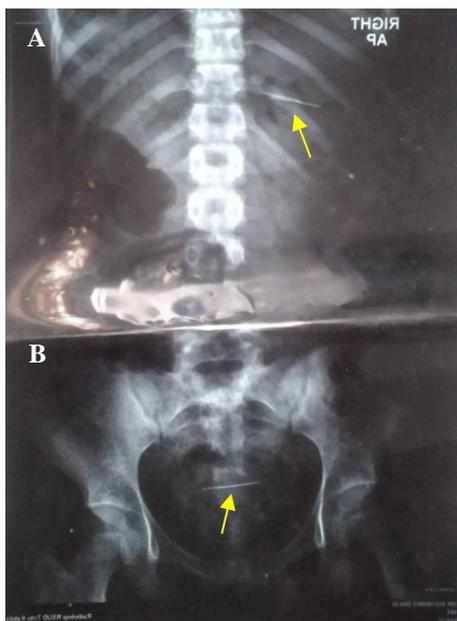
Abdominal X-ray revealed a linear body shape with two impressions on the right hypochondrium at the level of XI thoracic costovertebral joint and in the pelvic cavity
